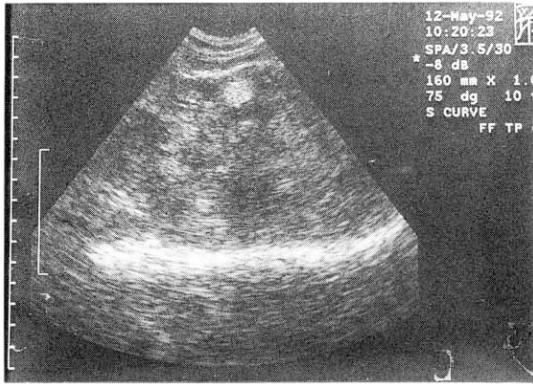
Ultrasonography of the liver showing inhomogeneous mildly echogenic mass with well defined small echogenic nodules.
